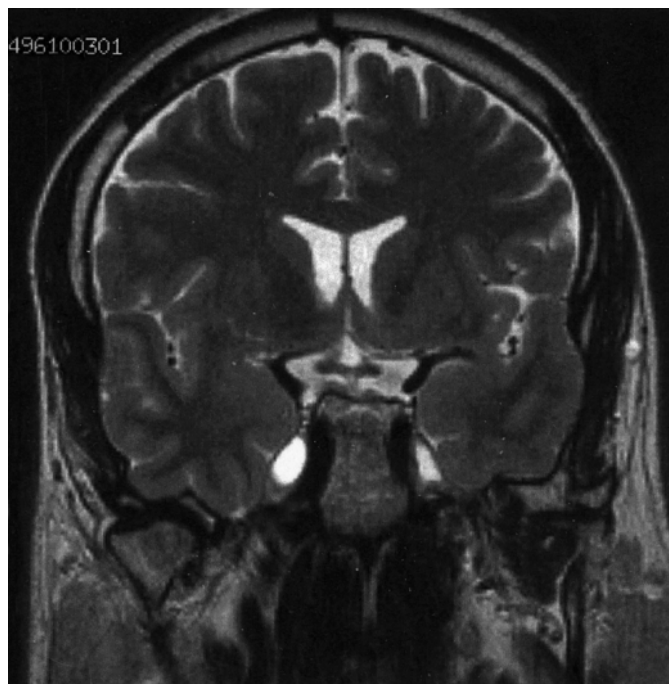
Arachnoid cyst of Meckel's cave (MRI, T2, Slice-thickness 5 mm).
